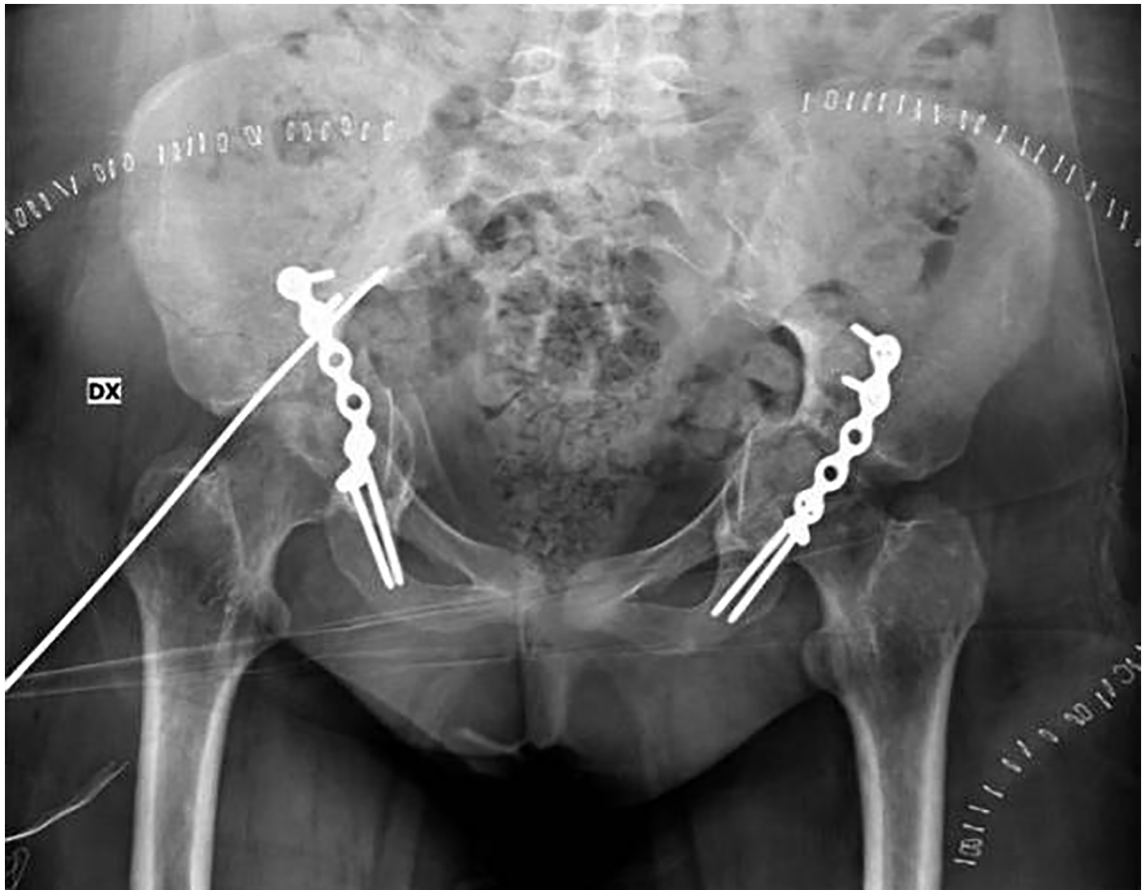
X-ray control after the first surgical time that consisting in the implant of a posterior pelvic plate and a Kirschner wire in order to maintain the femoral head relocation.
